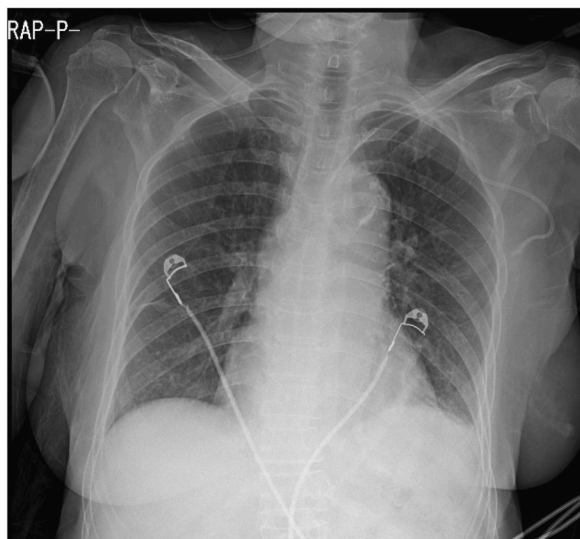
Chest X-ray on POD1.
